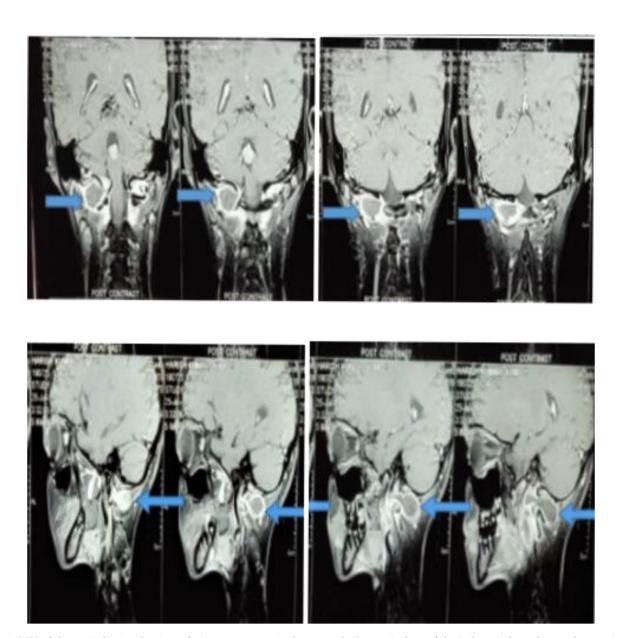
MRI of the cervical spine showing soft tissue component in the prevertebral space in front of the 2nd cervical vertebrae with a maximum thickness of 1.8 cm with peripheral contrast enhancement.
